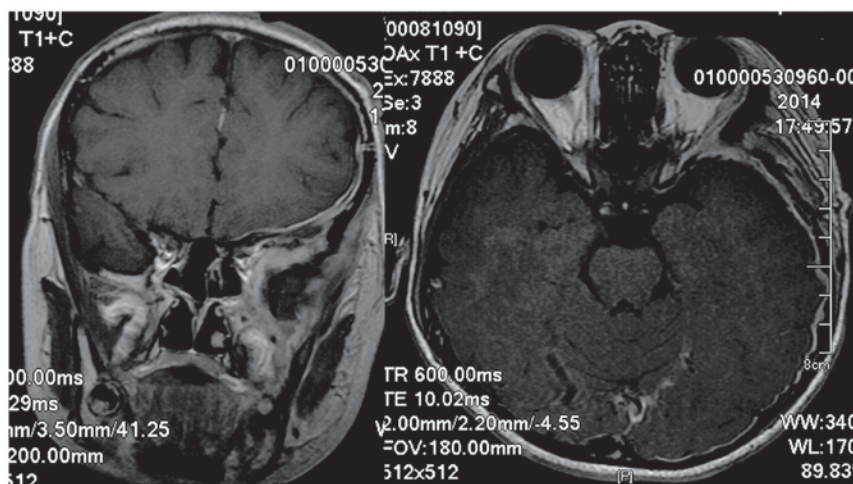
Follow-up magnetic resonance imaging revealed no residual tumor matter or recurrence.
